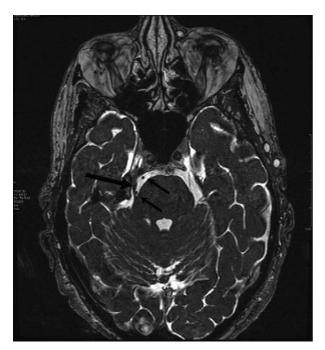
Magnetic resonance image displaying constructive interference in steady-state sequence (3-dimensional volumetric thin slice, T2 weighted) through the level of the mid-pons demonstrates a loop of the right superior cerebellar artery (small arrows), the lower limb of which abuts the right trigeminal nerve (large arrow) as it exits the pons.
